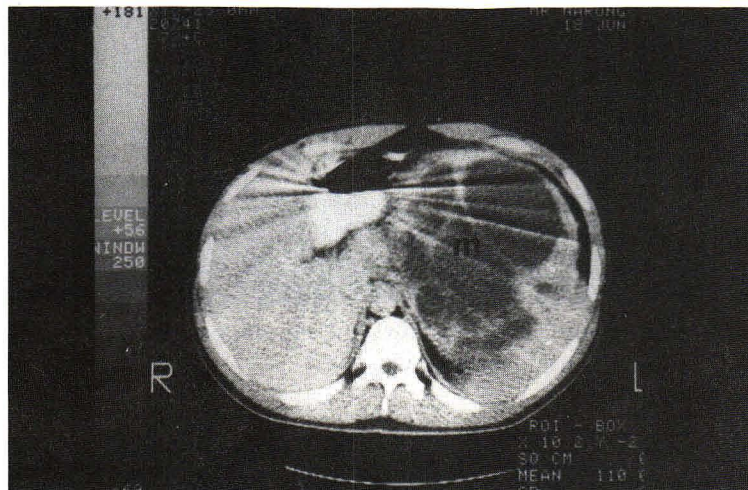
An enhanced axial CT scan shows a thickwalled cystic mass with enhanced cepta and nodular thick wall (m) in the left kidney.
